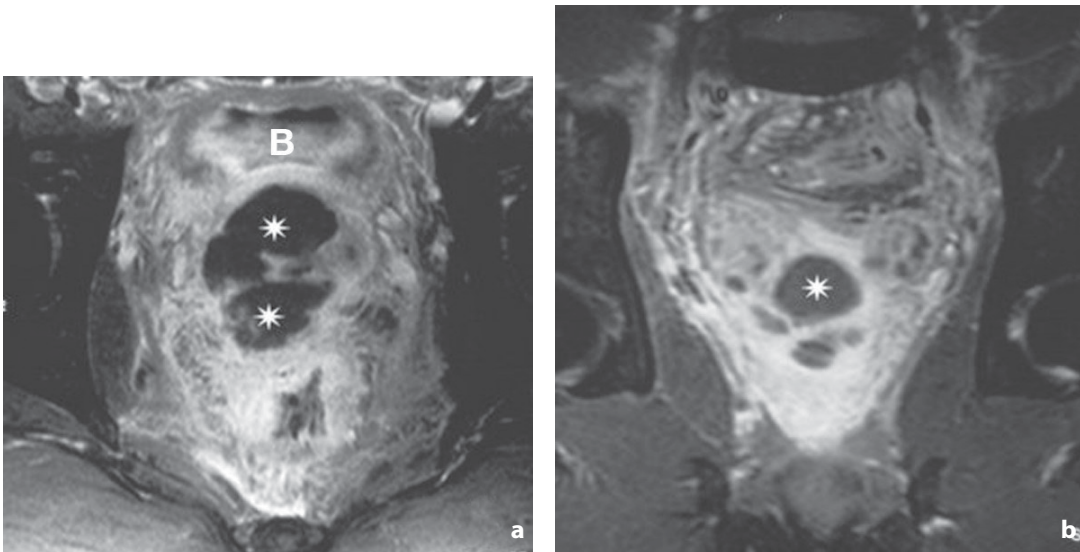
Magnetic resonance. Axial (a) and coronal (b) T2-weighted images. Complete subversion of the prostatic area by a necrotizing inflammatory process (*asterisks*) which involve the surrounding soft tissue with significant edema. *B*, urinary bladder
